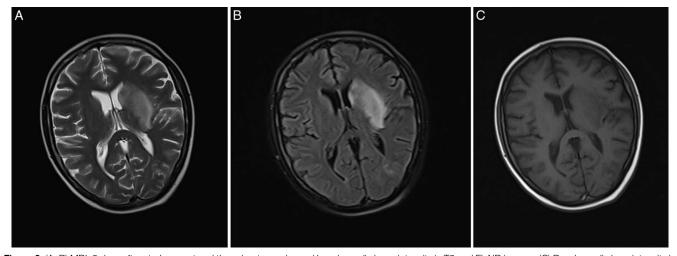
(A, B) MRI, 3 days after stroke onset and thrombectomy showed basal ganglia hyperintensity in T2 and FLAIR images. (C) Basal ganglia hypointensity in T1 weighted images.
